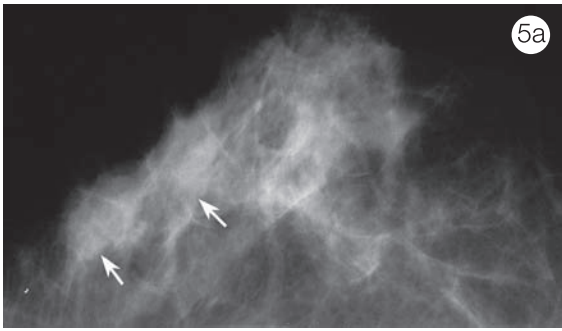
(a) Granulomatous mastitis 2 years after pregnancy presents with subtle asymmetric density on mammography (arrows) at the location of the palpable mass. (b) Ultrasound image reveals a heterogeneously hypoechoic tubular mass with ill-defined margins surrounded by hyperechoic boundaries.
